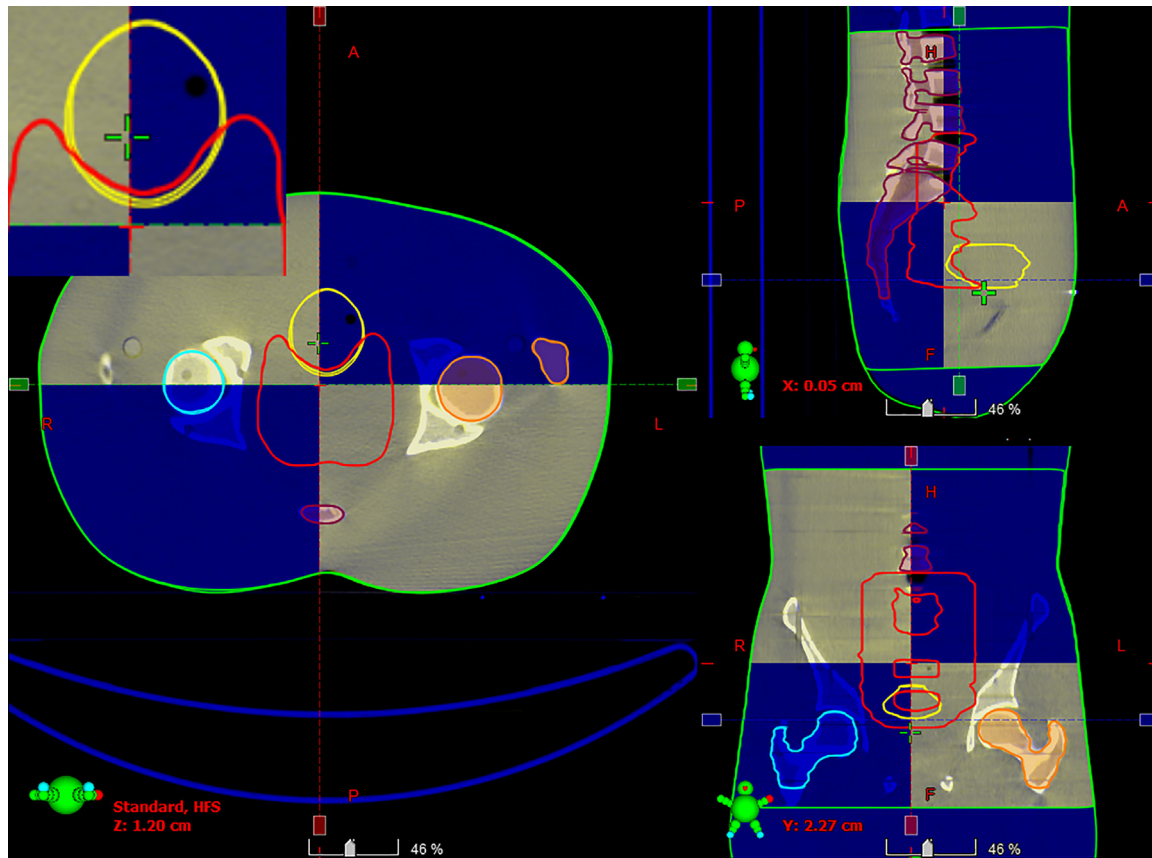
Rigid registration between pCT (shaded blue) and S₁-CBCT showing optimal match with minor changes in the mapped structures.
